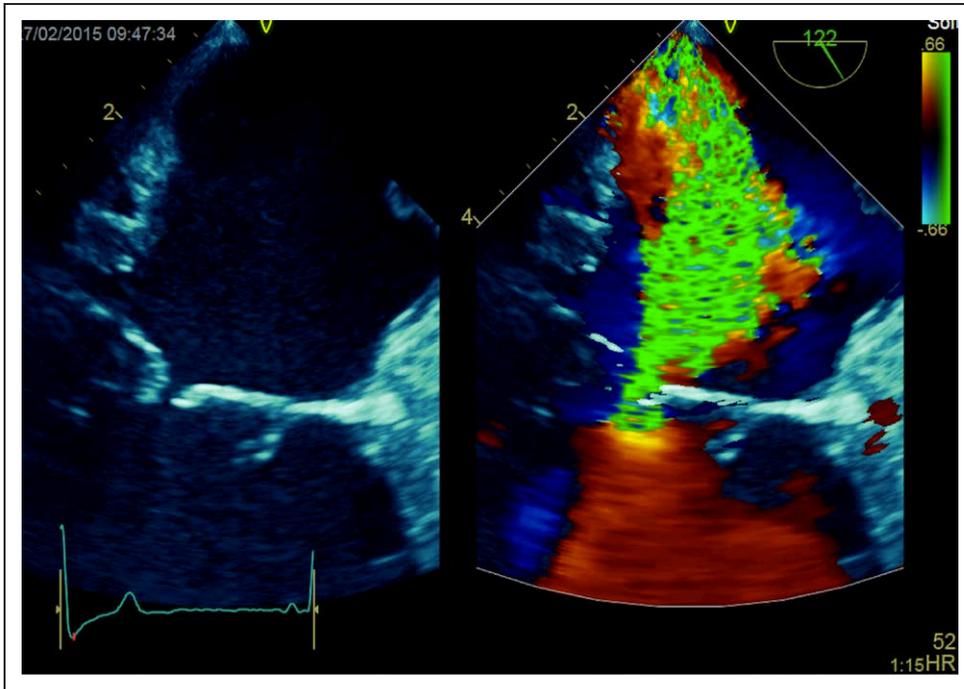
Transesophageal echocardiogram: mid-esophageal long-axis view showing malcoaptation of the mitral valve leaflets.
